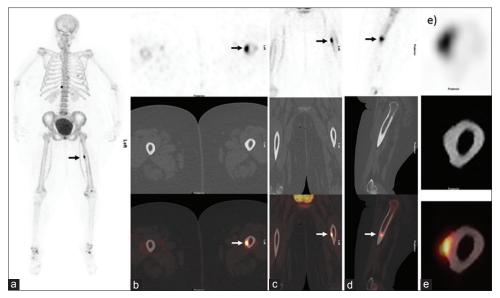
(a) Anterior maximum intensity projection images showing focal spindle-shaped area of increase tracer uptake at upper shaft of left femur (arrow). Increased sodium fluoride uptake also seen at degenerative/arthritic changes at osteophyte at D11, end plates of L4/L5 vertebrae, both knees, and ankle joints. (b-d) Cross-sectional <sup>18</sup>F-sodium fluoride positron emission tomography–computed tomography (e) zoomed transaxial images showing focal area of increase tracer uptake at posteromedial cortex of upper shaft of left femur (arrow); corresponding computed tomography showing periosteal thickening with central linear lucency. Findings are likely due to adductor insertion avulsion syndrome with stress fracture
